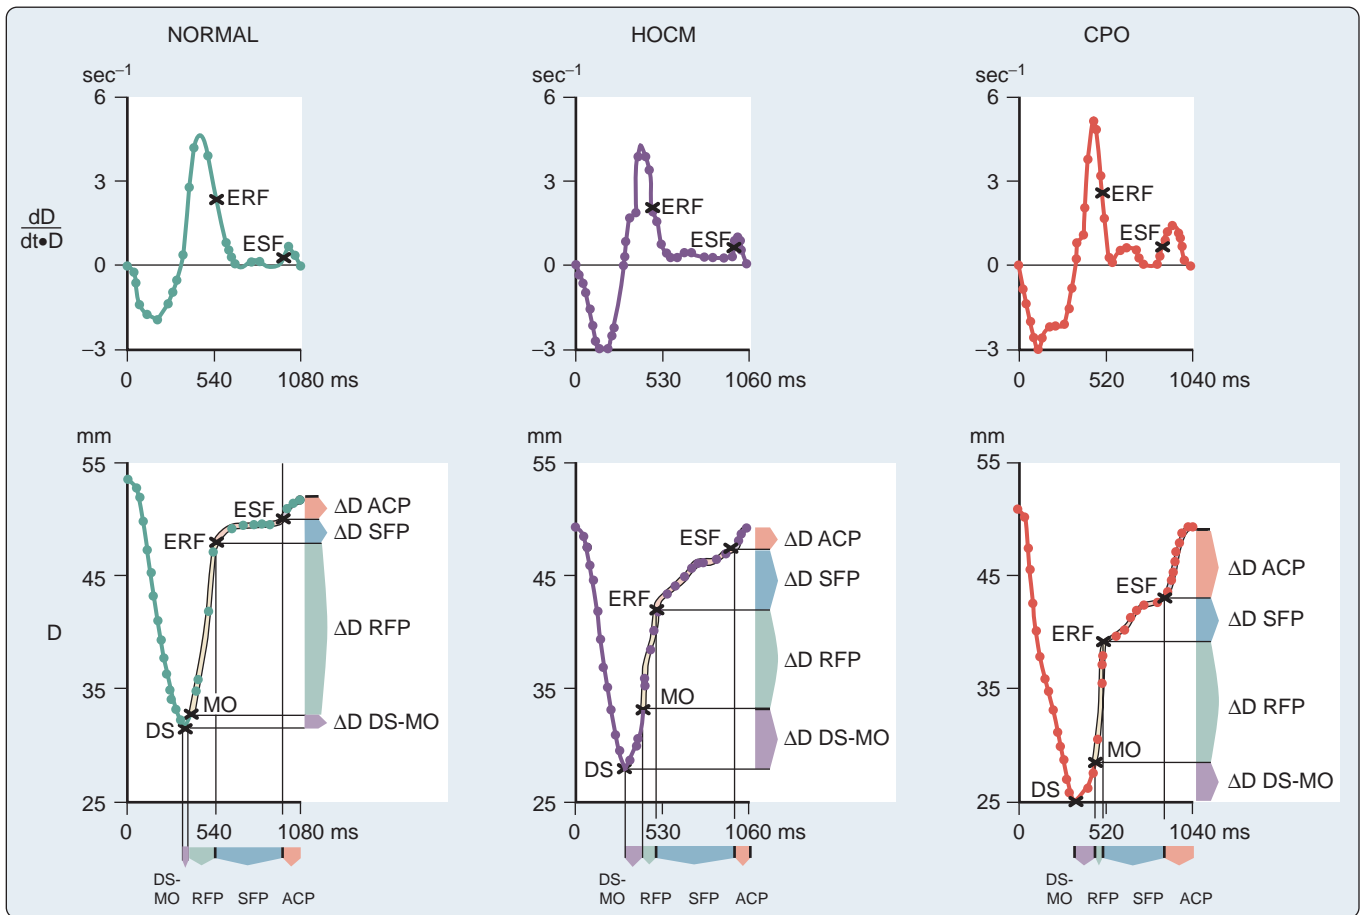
Computer-generated echograms of left ventricular (LV) cavity size in healthy subjects and patients with ventricular hypertrophy (ie, hypertrophic obstructive cardiomyopathy [HOCM] or chronic pressure overload [CPO]). Top panels show the rate of ventricular dimensional change. In the bottom panels, for patients with both forms of hypertrophy, the mitral valve opening (MO) with regard to the end-systolic LV dimension (DS) is delayed, and the dimensional change during this interval (ΔD DS-MO) is abnormally large. The duration of the rapid-filling phase (RFP) and the volume change during this interval (ΔD RFP) are correspondingly reduced. This is followed by a large dimensional increase during the atrial contraction phase (ΔD ACP) in the patient with chronic pressure overload; ERF, End point of rapid filling phase; ESF, end point of slow filling phase; SFP, slow filling phase. (From Hanrath P, Mathey DG, Siegert R, et al. Left ventricular relaxation and filling pattern in different forms of left ventricular hypertrophy: an echocardiographic study. *Am J Cardiol.* 1980;45:15.)
